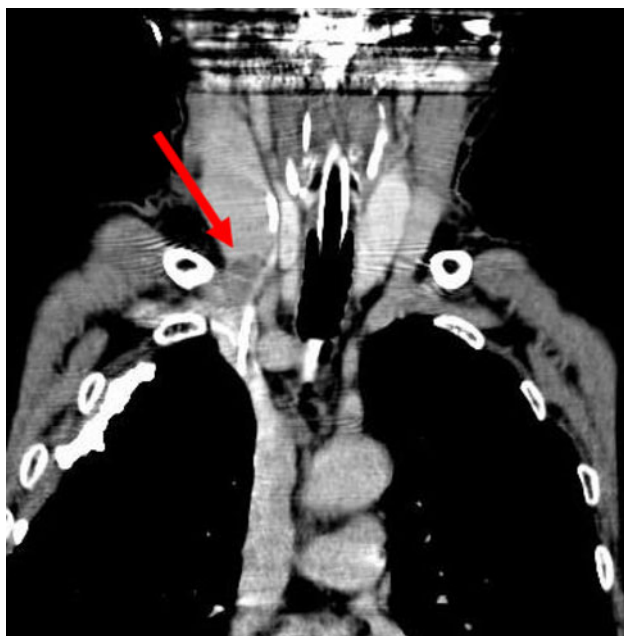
Chest computed tomography (CT) showed that the internal jugular vein was kinked at the inlet portion of the thorax. Arrow indicates venous thrombus in internal jugular vein
